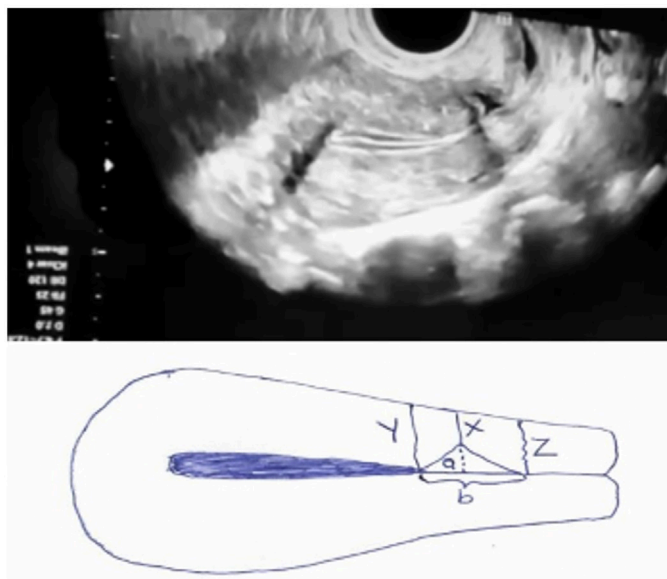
The measured parameters with ultrasound
